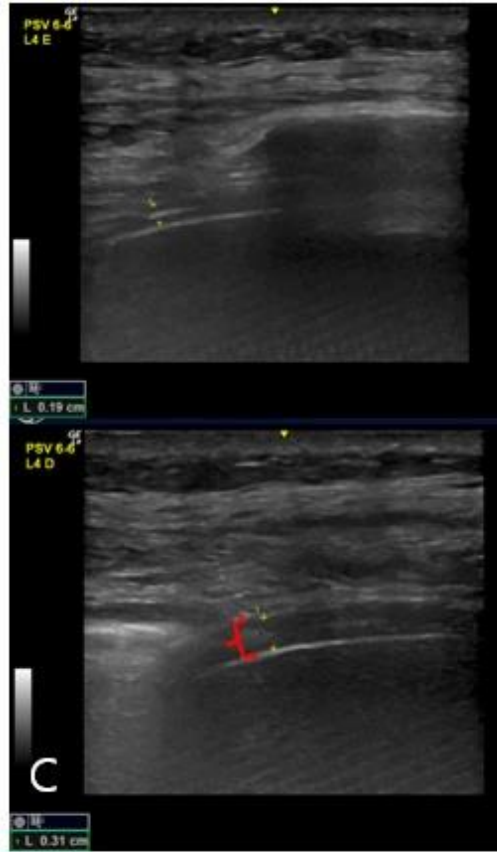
(A) CXR, on POD1. (B) Elevation of the left diaphragm on POD 7. (C) Changes in the left diaphragm thickness during DB by US on POD 1. (D) Absence of contraction of the left diaphragm during DB on POD 7. *CXR, Chest x-ray, POD, postoperative day, DB, deep breathing, US, ultrasound
